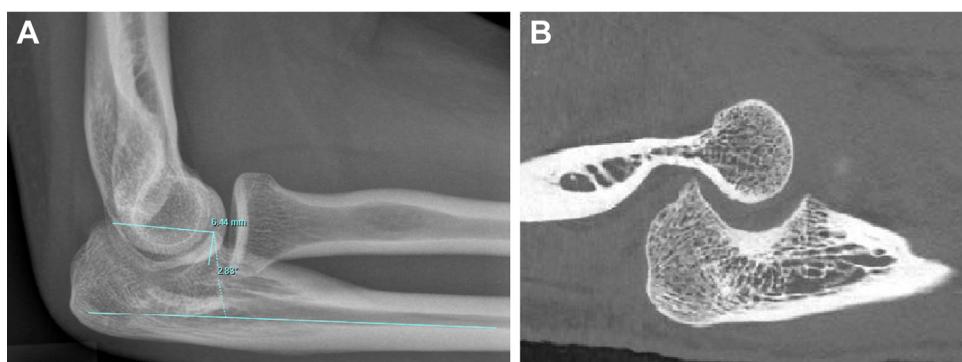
Radiographs (A) and CT scan (B) showing dysplasia of the greater sigmoid notch in a 27-year-old female with severe instability and persistent elbow dislocations. Coronoid height in this patient is around 6.4 mm (normal values between 13 and 19.6 mm) and olecranon-coronoid angle in this patient is -2.8° (normal value varies between 18° and 28°), indicating severe dysplasia.⁸ CT, computed tomography.
